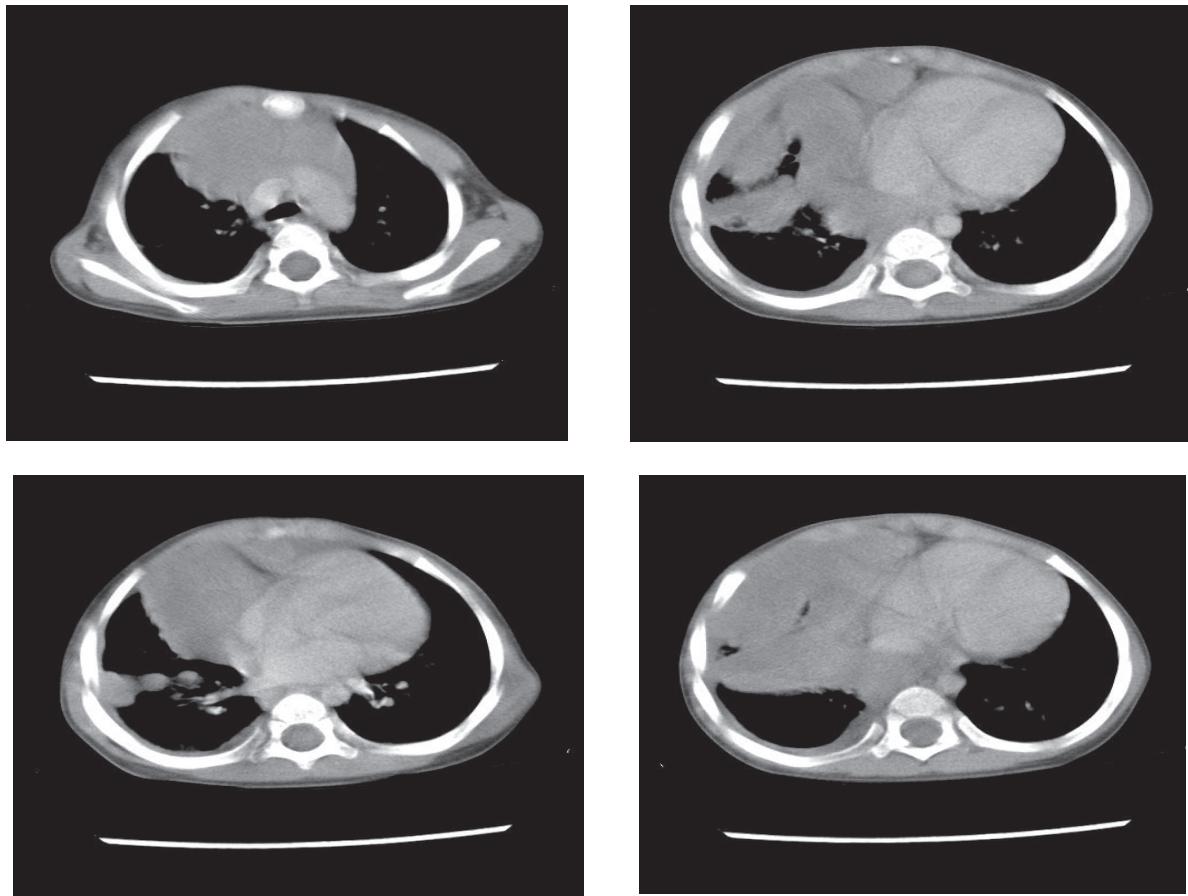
(A-D). Chest CT of the 2nd recurrent episode (December 2017)
